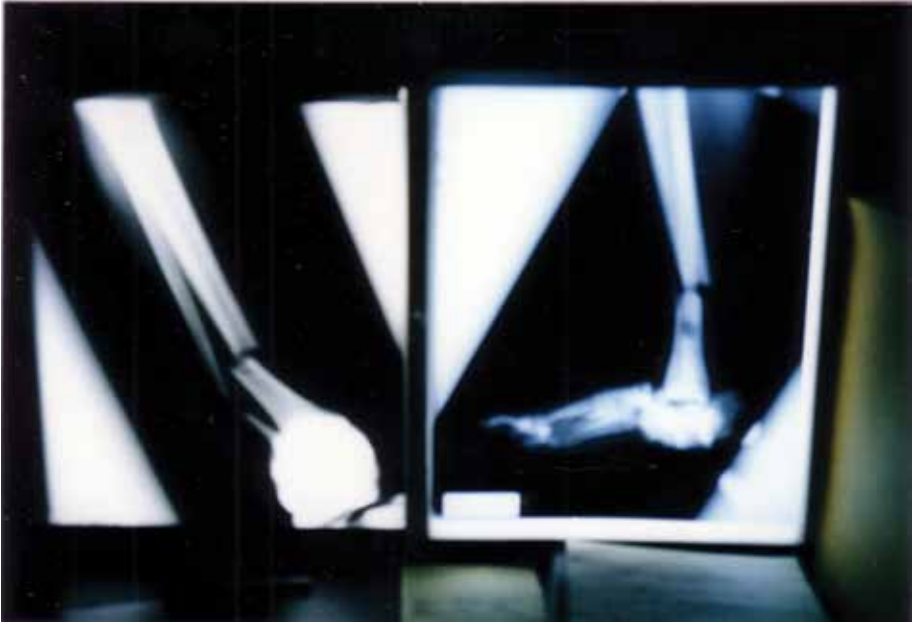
X-rays of a landmine injury cared for at the 212th MASH.
